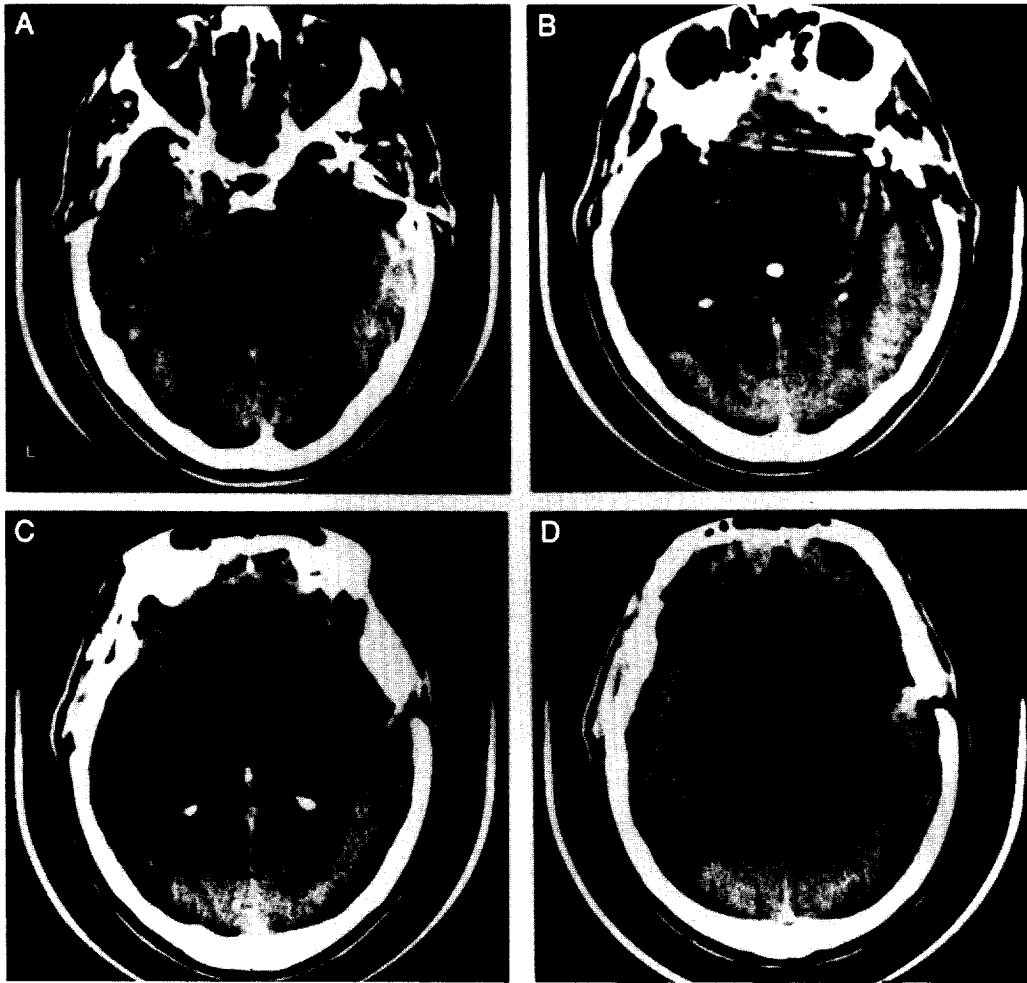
Case G.L. Contiguous, 10 mm thick, horizontal CT sections obtained without intravenous contrast in July 1990, ~9 years after G.L.'s second craniotomy. Hypodensities are seen in the superior temporal gyri (B–D), temporal poles (B–D), inferior frontal gyri (D) and insulae (B–D) of both hemispheres, and in the transverse gyrus of Heschl (C–D), inferior parietal lobule (D) and middle temporal gyrus (B–C) of the left hemisphere. Additional hypodensities in the left inferior parietal lobule appear in the section superior to D (not shown). Aneurysm clip artefacts are seen in A and B.
